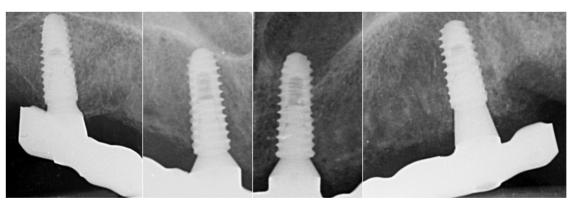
Radiographic evaluation at the last follow-up.
